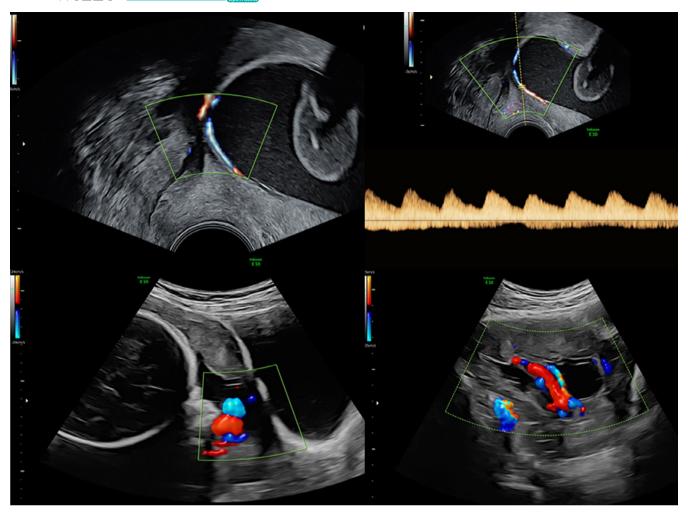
Case 5: Visualization of fetal vessels overlying the cervical os and a bilobate placenta using color-coded Doppler ultrasound (transvaginal)—ultrasound of the same case showing the bilobate placenta and the vessels crossing over the cervix (transabdominal)
